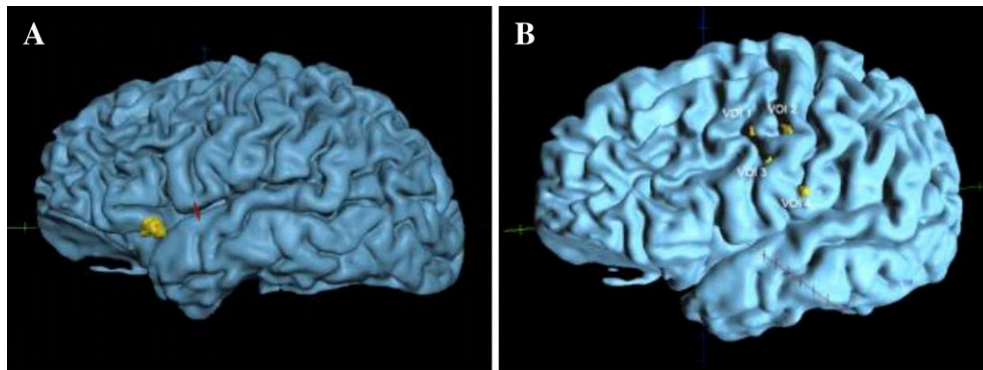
Volumetric reconstruction of axially acquired 3D T1-weighted sequences with blood-oxygen level-dependent imaging clusters shown to be significantly different in Instructor baseline vs. post-exposure (A) and in Instructor post-exposure vs. Student post-exposure (B) superimposed in yellow. Frame A demonstrates a single significantly different cluster in Brodmann area 47 [random effects GLM: $t_{(7)} \geq 4.00$ or ≤ -4.00 , $p \leq 0.005$]. Frame B demonstrates 4 significantly different clusters, with 2 centered in Brodmann area 3, 1 in Brodmann area 7, and another in Brodmann area 40.
